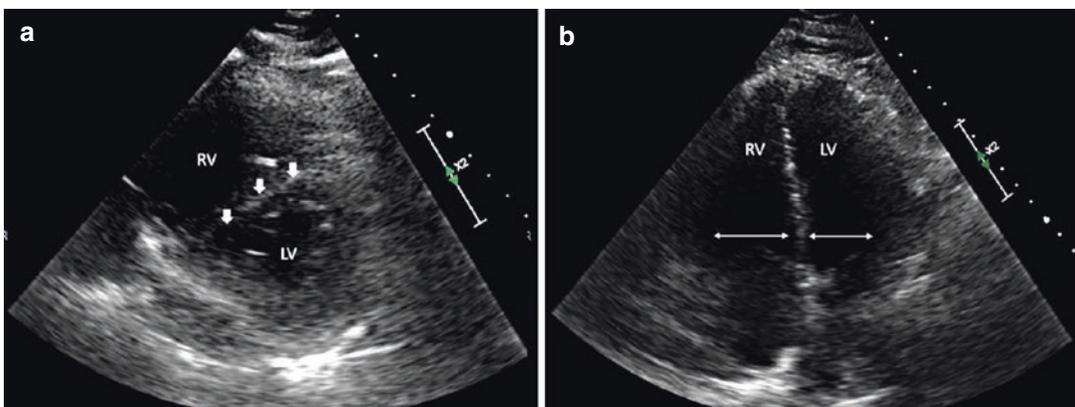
(a) Right ventricular (RV) strain seen on parasternal short axis view with the intraventricular septum (arrows) bowing into the left ventricle (LV). The result is
